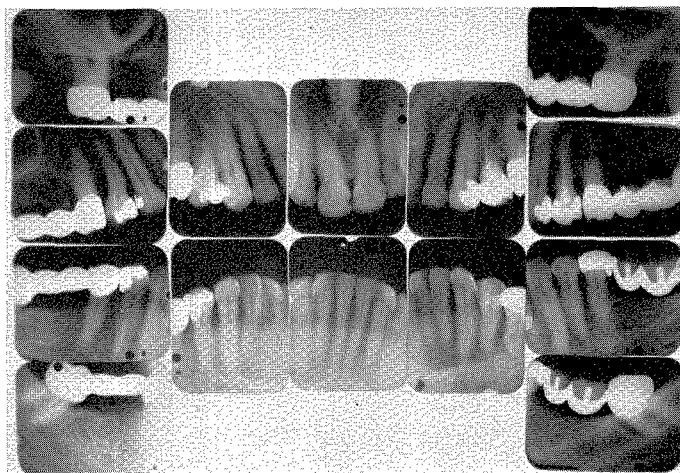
Roentgenograms taken in 1938. Four fixed partial dentures had been inserted in the fall of 1934.
